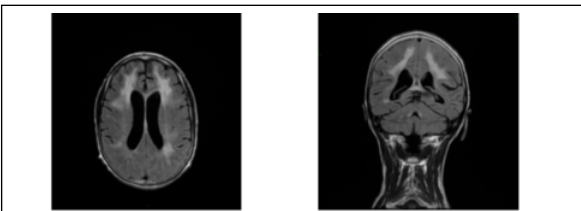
B: Axial and coronal FLAIR MRI (November 2013).
